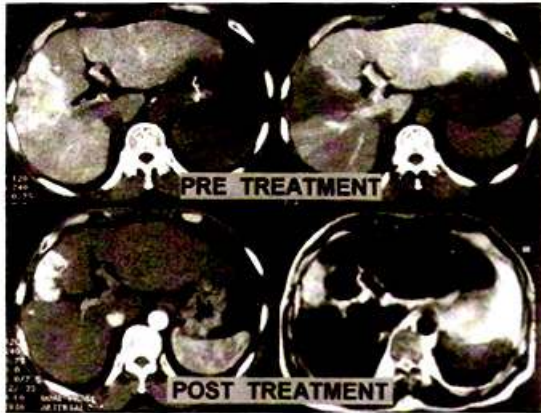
Pre-treatment dual-phase computed tomogram of liver showing vascular mass in segments IV and V, with reduction in size of mass after TACE
